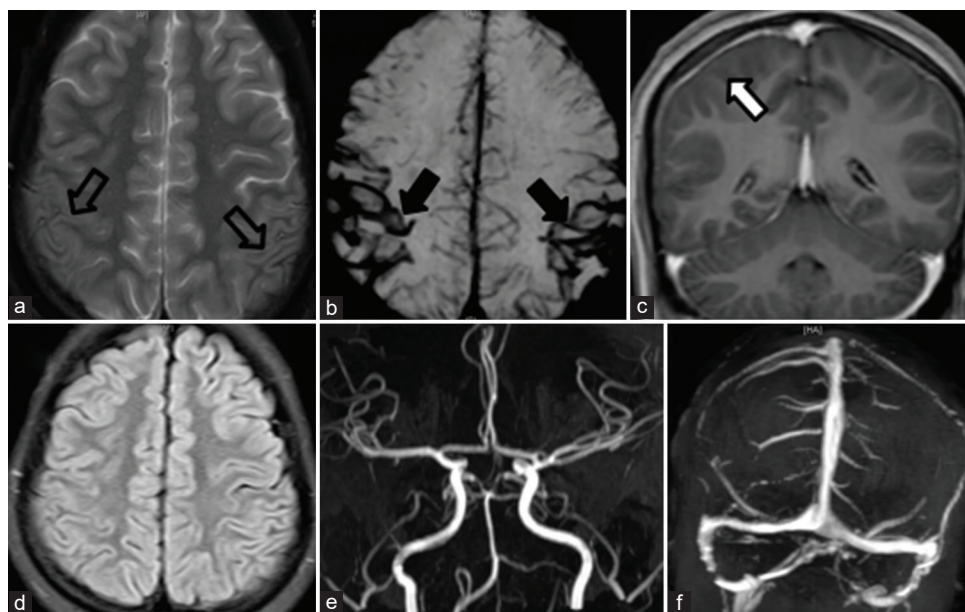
(a) T2W axial image showing curvilinear hypointensity (open black arrows) along the sulci in bilateral frontoparietal regions, consistent with hemosiderin, 'blooming' on the SWI sequence (solid black arrows) (b). (c) On T1W post-contrast sequence, the overlying dura shows reactive thickening and enhancement (white arrow), as a sequel of previous haemorrhage. (d) Corresponding FLAIR axial section did not show any parenchymal signal changes. (e) TOF MR angiogram with normal course and calibre of intracranial arteries. (f) Dynamic MR venogram showed normal venous sinuses and cortical veins
